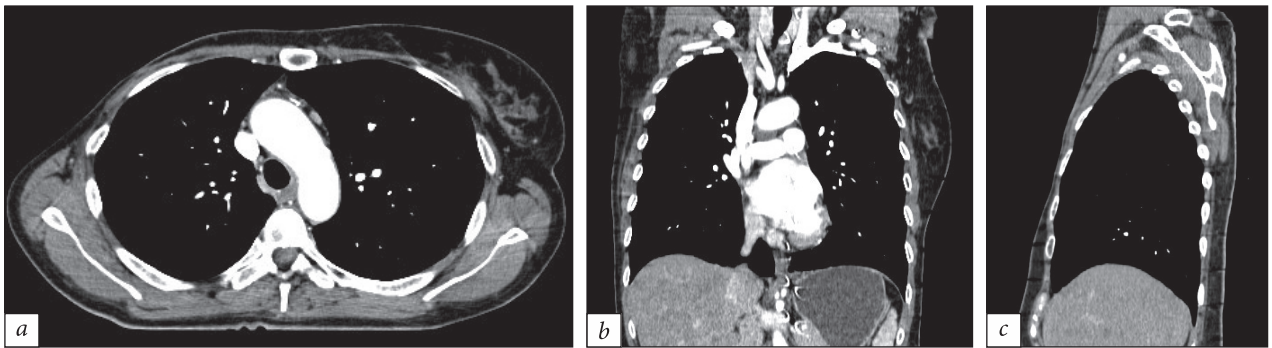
Postoperative computed tomography scan of the chest in axial (a), coronal (b), and sagittal (c) views along the course of the postoperative scar. No pathological formations were detected. Condition after NACT, right-sided mastectomy, and radical excision of the lymph nodes in the right armpit
